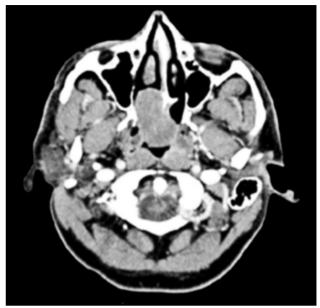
Axial computed tomography scanning image of the posterior nasal septal mass.
